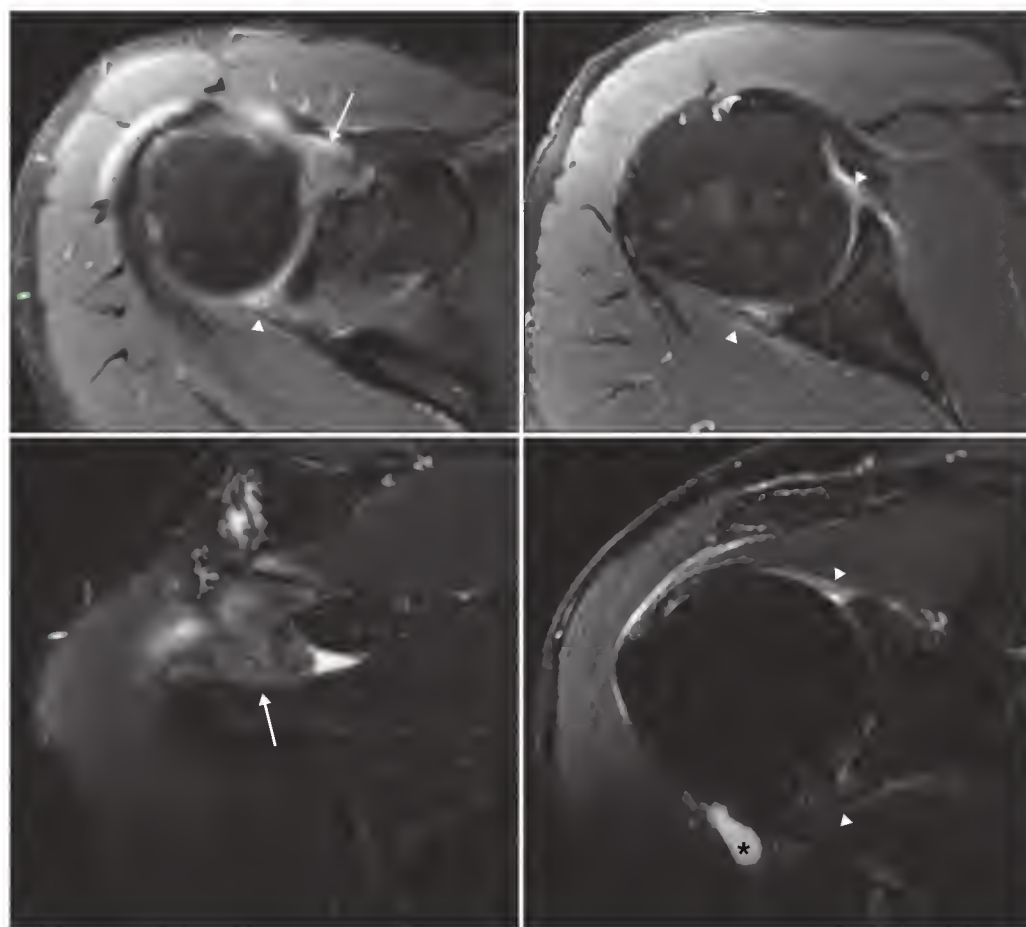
Nonarthrographic magnetic resonance images of capsulitis. Fat-suppressed images show hyperintense capsular and synovial thickening within the rotator interval (arrows) and diffuse hyperintense thickening of the glenohumeral joint capsule (arrowheads) with an accompanying small joint effusion (asterisk).
